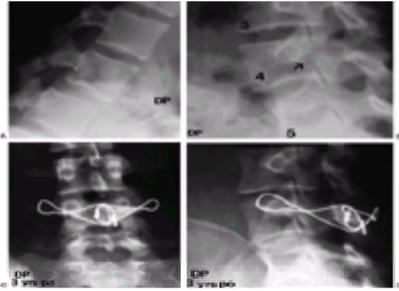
A 14-year-old girl was seen for chronic low back pain. She had bilateral pars fractures at L4, as seen on (A) lateral and (B) oblique radiographs (*arrow*, pars defect). The patient underwent bone grafting, with wiring of the defect with a spinous process transverse process wire. The wire position is seen on the posteroanterior view (C), and the solid fusion is seen on the oblique view (D). She was rendered free of pain and returned to full activity.
